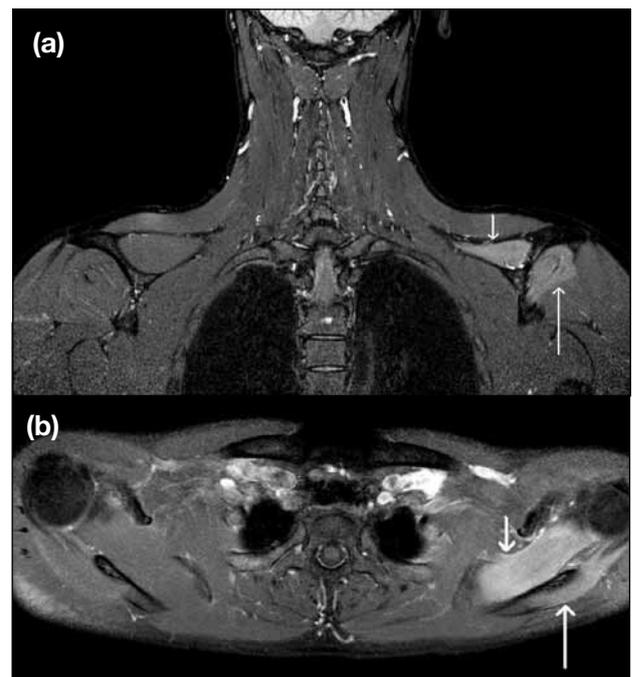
A sagittal T2-weighted fat-saturated image showing hyperintense signal limited to the supraspinatus (short arrow) and the infraspinatus muscle (long arrow). Note that the rest of the rotator cuff muscles show normal signal intensity.
